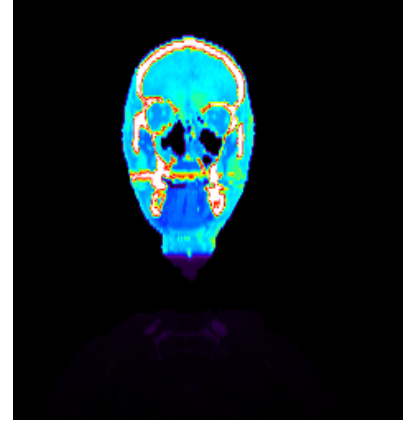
Central slices for Pat. B for a single beam at 0° . The slice positions are marked in the CT-slices shown in (n) - (p).
